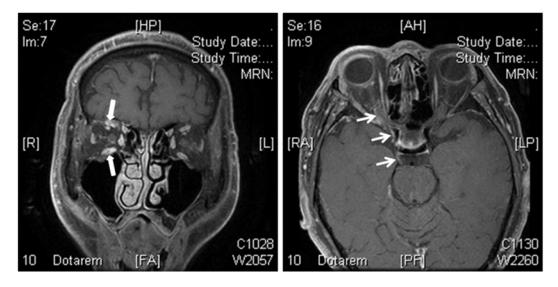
Post-contrast T1-weighted coronal and axial MRI: A) Enhancement and thickening of the right-sided extraocular muscles especially the superior rectus and inferior rectus muscle (wide arrow) B) Enhancement and thickening of the cisternal, intracavernous and intraorbital portions of the right third cranial nerve (narrow arrow)
